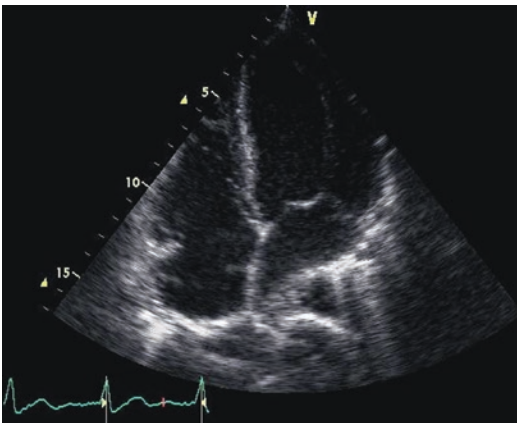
Trans-thoracic echocardiogram 4-chamber view showing enlargement of both left and right ventricles consistent with a dilated cardiomyopathy
